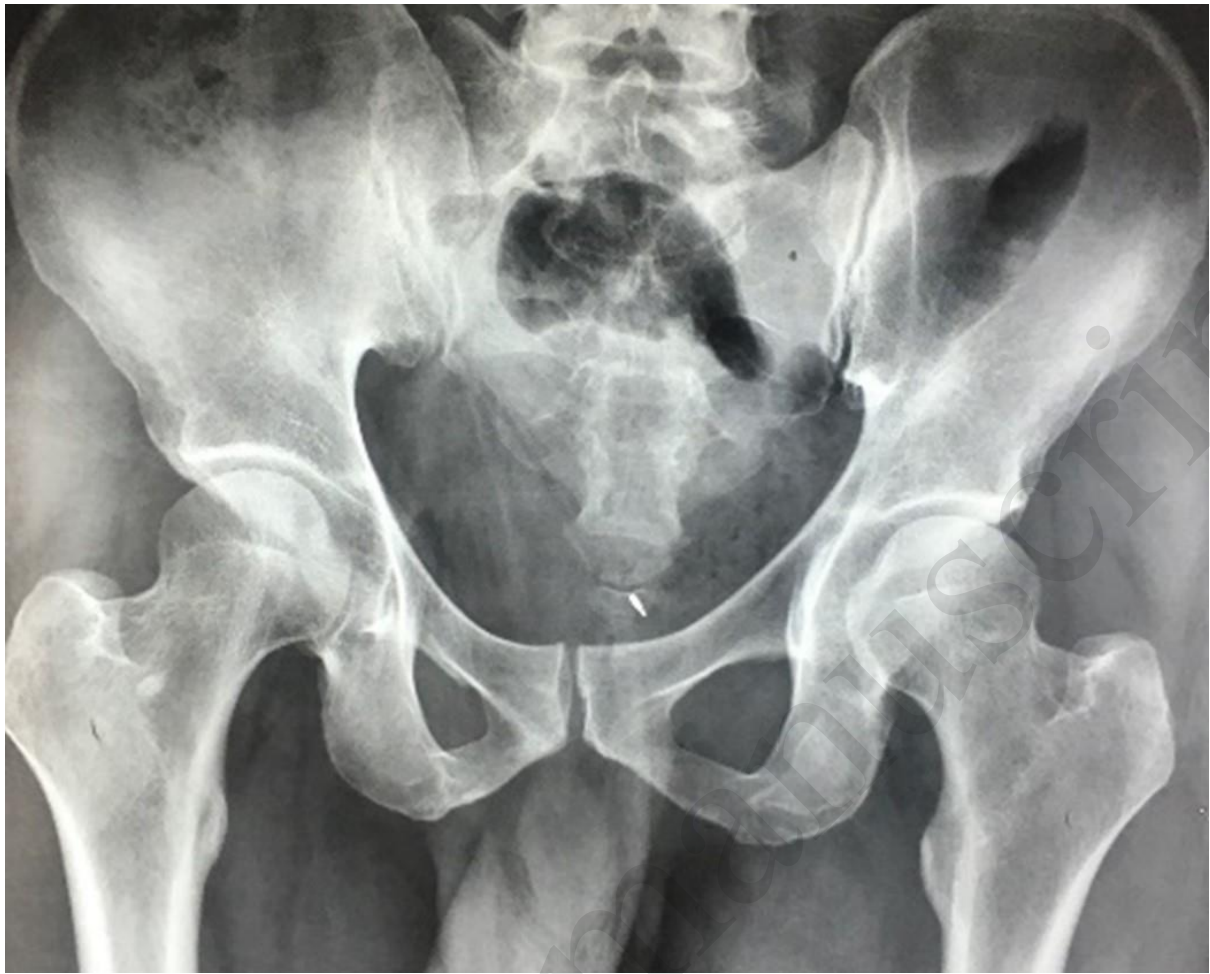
X-ray of the pelvis depicting the metal portion of a linear foreign body within the bladder region
